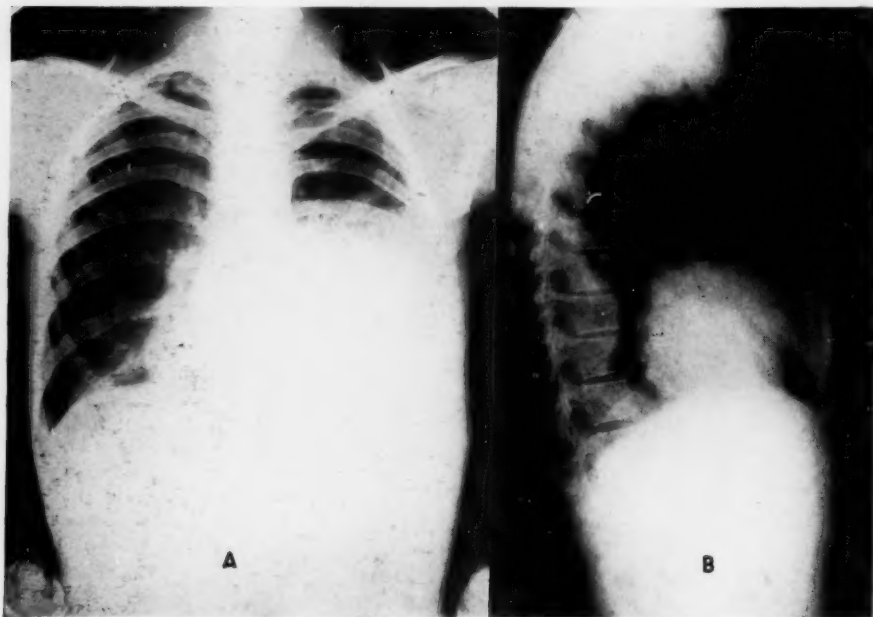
(A) Postero-anterior roentgenogram of a patient with thoracic actinomycosis, at time of admission, February, 1931 (Table II, Case 2). (B) Left lateral exposure. Showing mass in the left lung.
